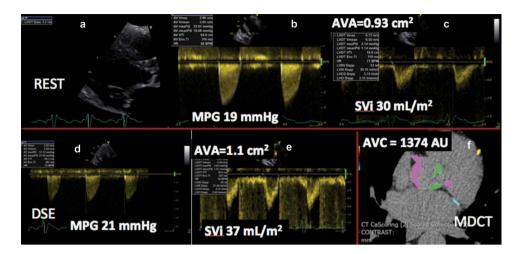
Dobutamine stress echocardiography (DSE) in a male patient with low flow low gradient AS and reduced left ventricular ejection fraction (LVEF = 28%). At rest, the severity of AS was unknown, (aortic valve area (AVA) = 0.9 cm^2 , mean pressure gradient (MPG) < 40 mmHg) (Panel a, b, c and d). With dobutamine stress echocardiography (DSE), there was a significant increase in flow reserve (change in stroke volume index (SVi) of 23%) (Panel e); MPG remained <40 mmHg, and AVA reached 1.1 cm² suggesting a pseudo-severe AS (Panel e and f). A MDCT indicated an AVC score of 1374 AU, which confirmed that the stenosis was not severe (Panel f).
